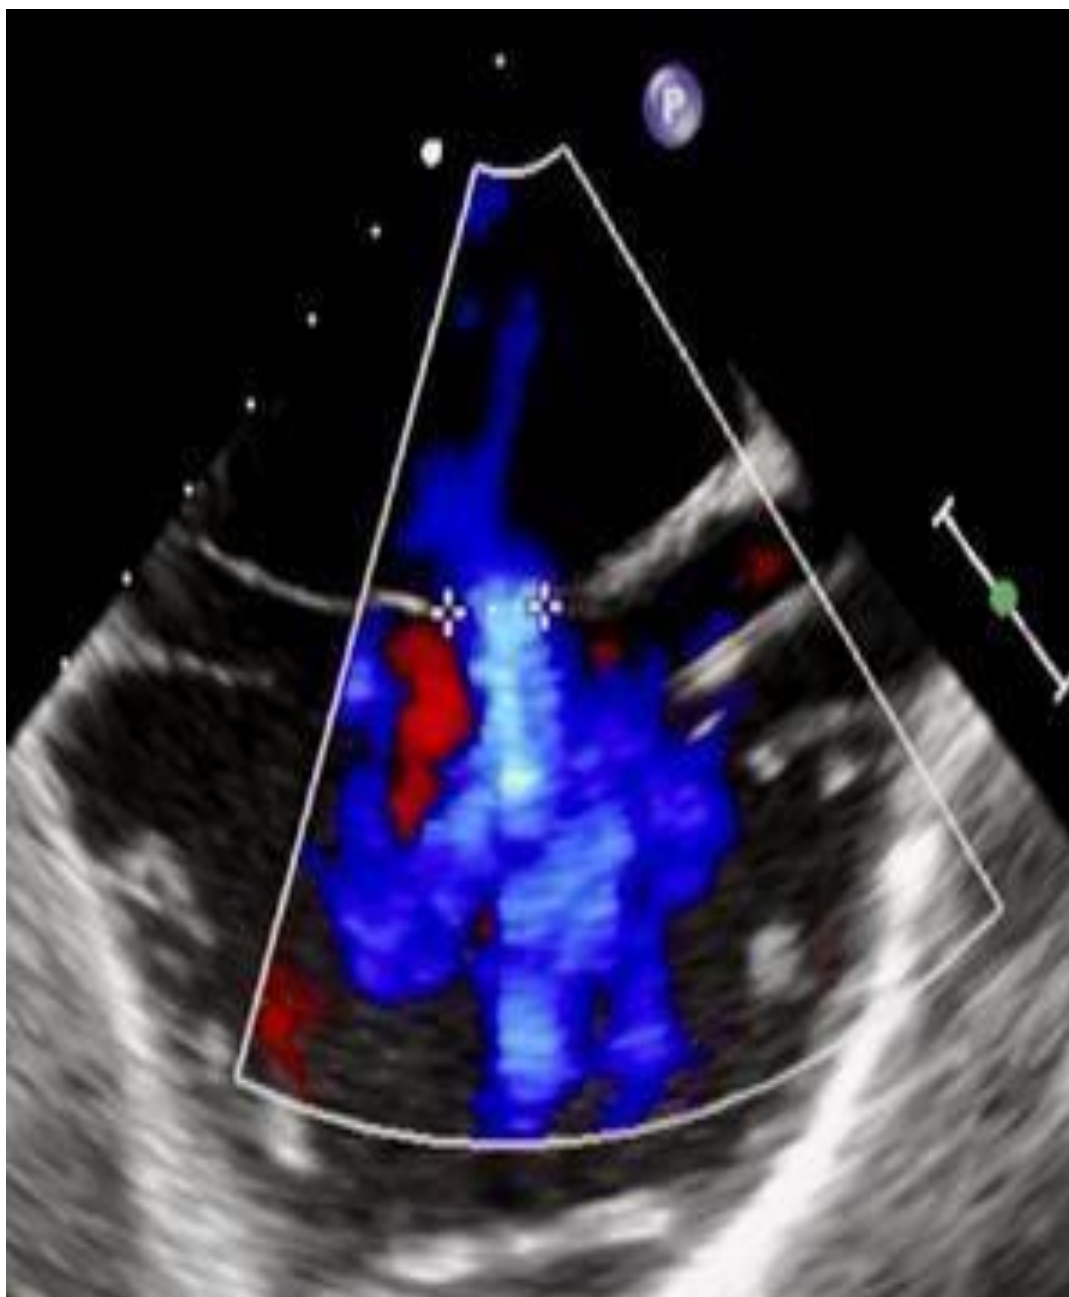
Transesophageal echocardiography (TEE) image, showing large ASD (1.09 cm) with left-to-right shunt.
